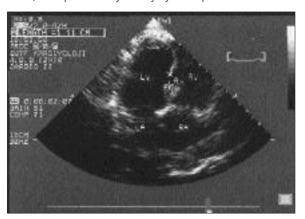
Two-dimensional transthoracic echocardiogram shows ruptured interventricular septum in the apical 4-chamber view.
